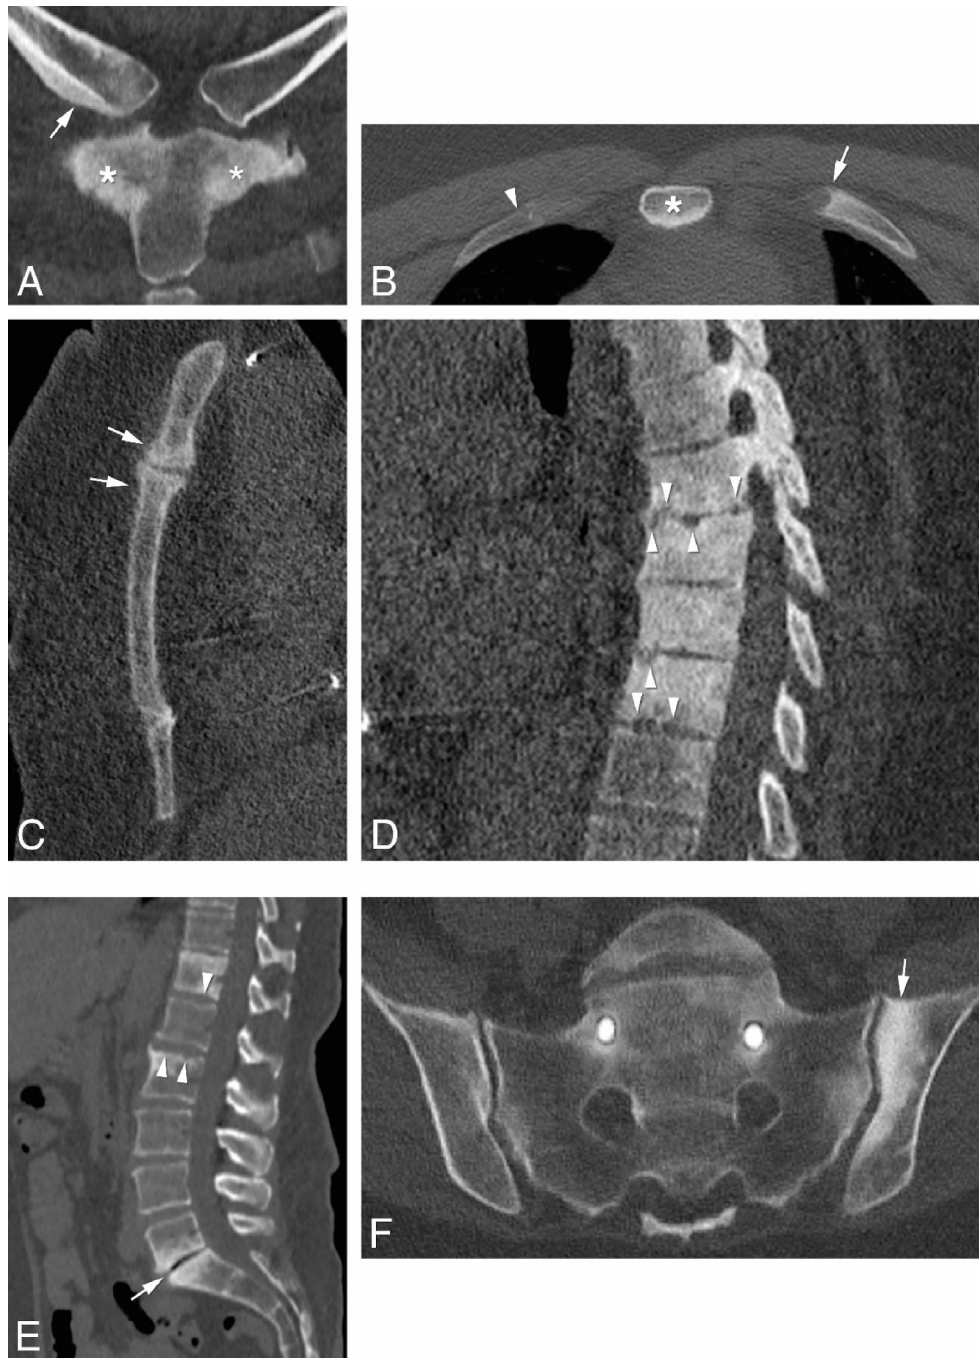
Examples of common locations of (osteo)sclerosis in adult CNO and pitfalls. A: (coronal CT view) osteosclerosis and mild hyperostosis in the medial end of the right clavicle (arrow), associated with hyperostosis and osteosclerosis of the manubrium sterni (asterisks), at the level of the first costosternal joint bilaterally. B: (axial CT view) osteosclerosis in the anterior right costal arch at the level of the second costochondral junction (arrow) to the left (note comparison to the contralateral rib, normal, arrowhead), and osteosclerosis of the corpus sterni (asterisk). C: (sagittal CT view) osteosclerosis in the sternum at the level of manubrium-corpus joint (arrows). D: (sagittal CT view) osteosclerosis in the thoracic spine (T4-T9), particularly in the vertebral corpora, with erosive changes in the adjacent endplates (arrowheads). E: (sagittal CT view) osteosclerosis with features of CNO in the lower thoracic (T12) and upper lumbar spine (L2) with subtle erosions (arrowheads), concurring with manifestations of osteoarthritis at the level of L5-S1: osteosclerosis limited to the endplates (Modic 3 changes), spondylophytes formation, narrowing of the joint space, and vacuum degeneration in the intervertebral disc (arrow). F: (axial CT view) osteitis condensans ilii is shown (a pitfall), more prominent on the left side (arrow), in a patient with sternal manifestations of CNO. Osteosynthesis material is seen in S1 due to previous spinal fixation.
